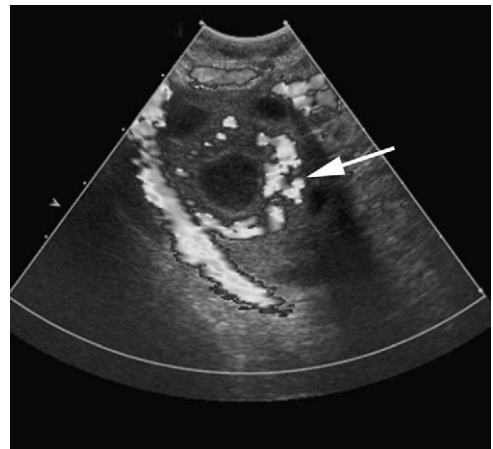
Corpus luteum cyst. Color Doppler image (shown in black and white) shows peripheral blood flow in the thick cyst wall (arrow). A corpus luteum cyst has a thicker, more echogenic, and vascular wall compared with a follicular cyst.
